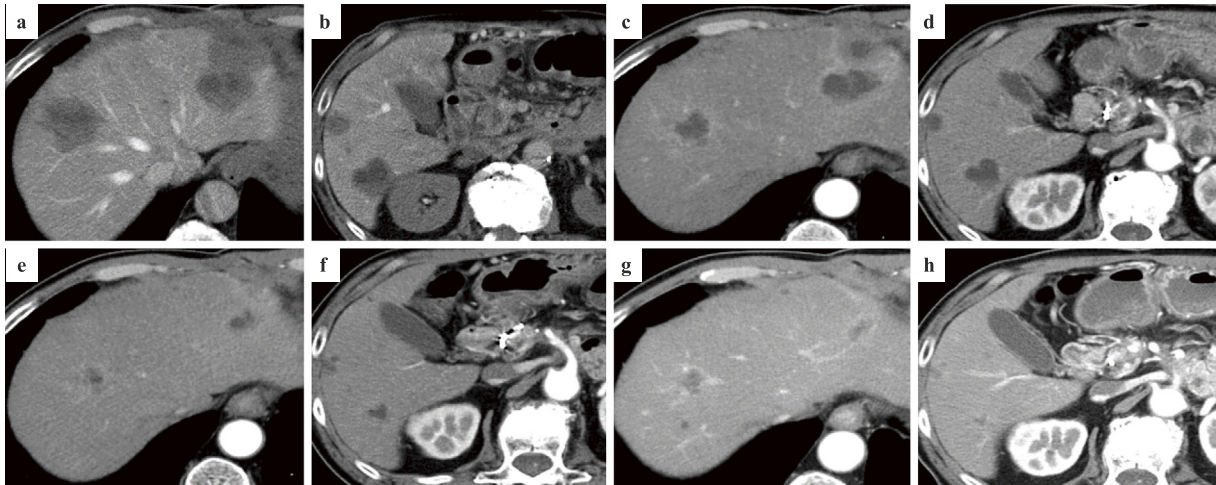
Follow-up contrast-enhanced computed tomographic image revealing a decrease in the size of the liver metastases. There was no local recurrence or distant metastasis except for the liver. (a, b) Computed tomography findings during arterial portography before HAIC; (c, d) after the second treatment cycle; (e, f) after the sixth treatment cycle; (g, h) after the 10th treatment cycle. HAIC: hepatic arterial infusion chemotherapy
